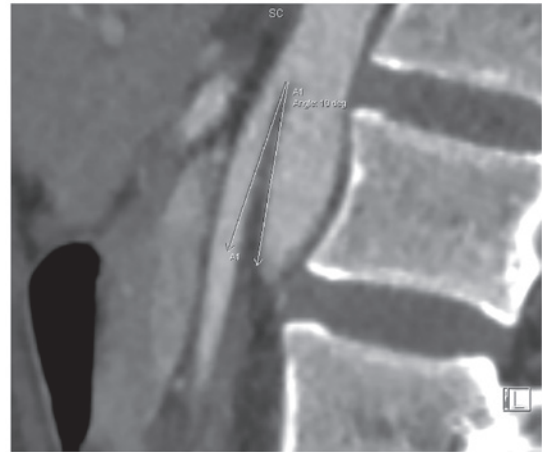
Sagittal slice of the computed tomography angiography scan of the abdomen shows that the superior mesenteric artery-aorta angle in the patient is $\sim 10^\circ$.
